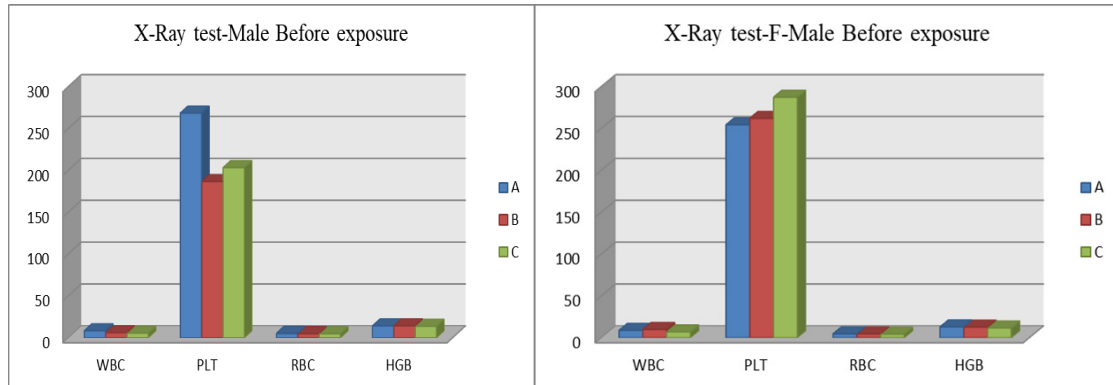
X-ray test Male & Female before exposure.
